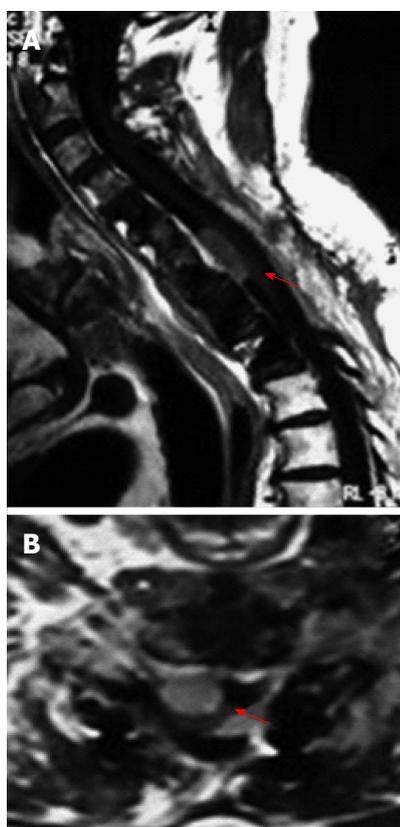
Magnetic resonance imaging of the cervico-thoracic spine at 3-mo follow-up showing (A) a small residual tumor, especially anteriorly to the cervical spinal cord and (B) axial view (red arrow).
